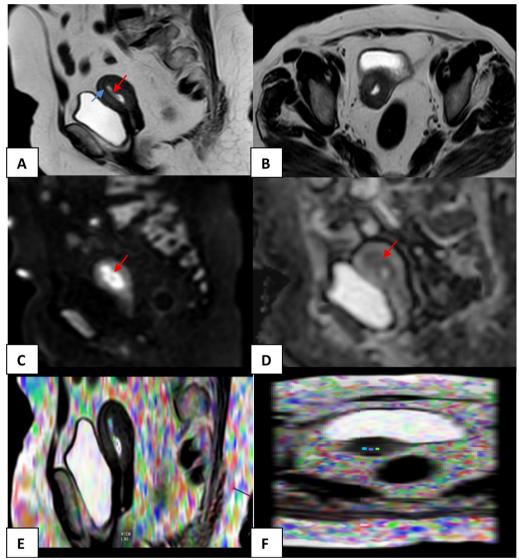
A 53-year-old postmenopausal female presented by abnormal vaginal bleeding. A, B *Sagittal and axial T2 WIs* irregular endometrial thickening which is occupied by a soft-tissue mass displaying intermediate SI (red arrow). No visible tumor breaching through the junctional zone (blue arrow). C *Sagittal DWI with b value of 1000 s/mm*² high signal intensity of the endometrial soft-tissue mass (red arrow). D *Sagittal DW-ADC map image*: low signal intensity of the endometrial soft-tissue mass (red arrow). Mean DW-ADC value = 0.939×10^{-3} mm²/s. E, F Sagittal and axial DTI map images: values of DT-FA and DT-MD in multiple ROI along the endometrial mass. Mean DT-FA value = 0.401, and mean DT-MD value = 0.962×10^{-3} mm²/s. *Diagnosis* Pathologically proved endometrioid adenocarcinoma G1
